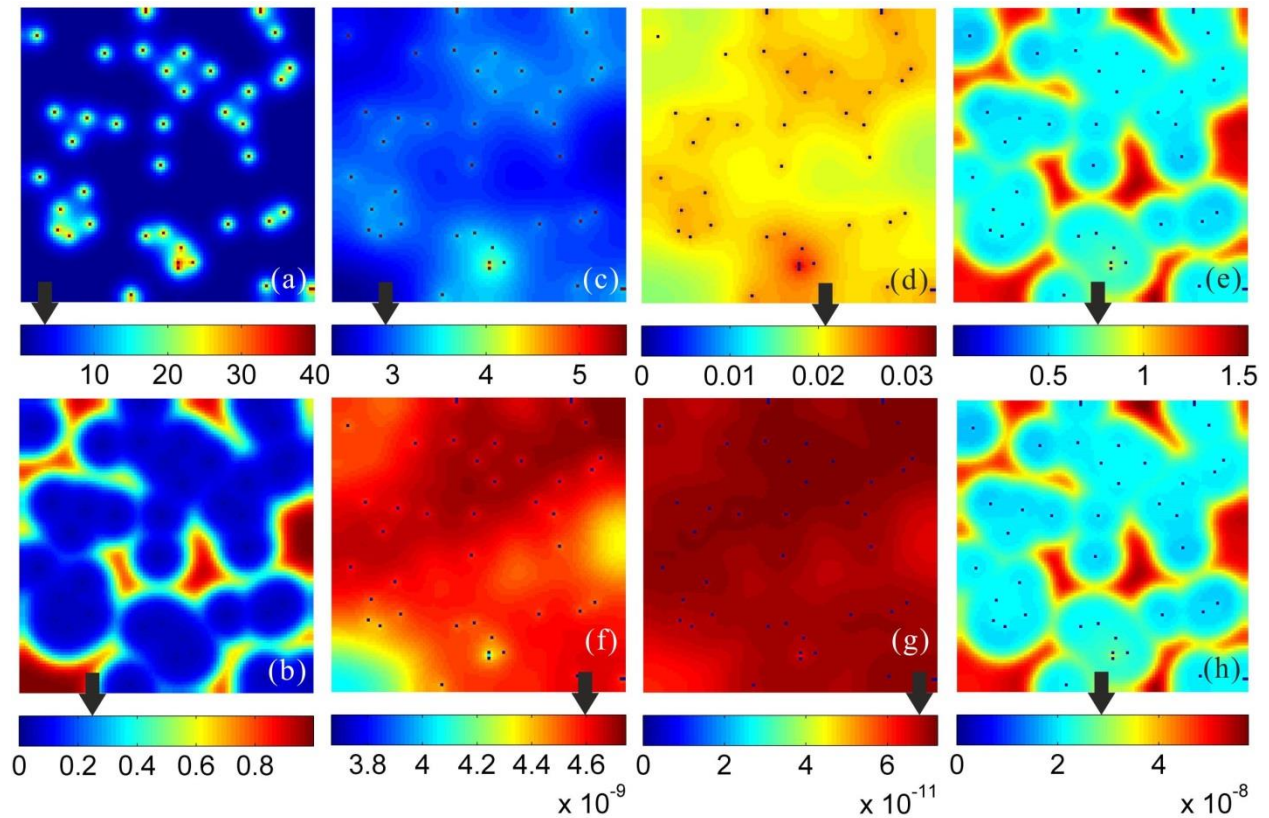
Substrate concentration maps. Figures (a) and (b) are the 2D oxygen (mmHg) and normalized HIF-1 distributions. Figures (c) to (h) present the 2D distributions of extra-, intra-cellular glucose (mM) and glucose metabolic rate ($\mu\text{M/s}$), and extra-, intra-cellular FDG (mM) and FDG trapping rate ($\mu\text{M/s}$), respectively. The average values of these parameters are marked by black arrows pointing to the colorbars of each map.
